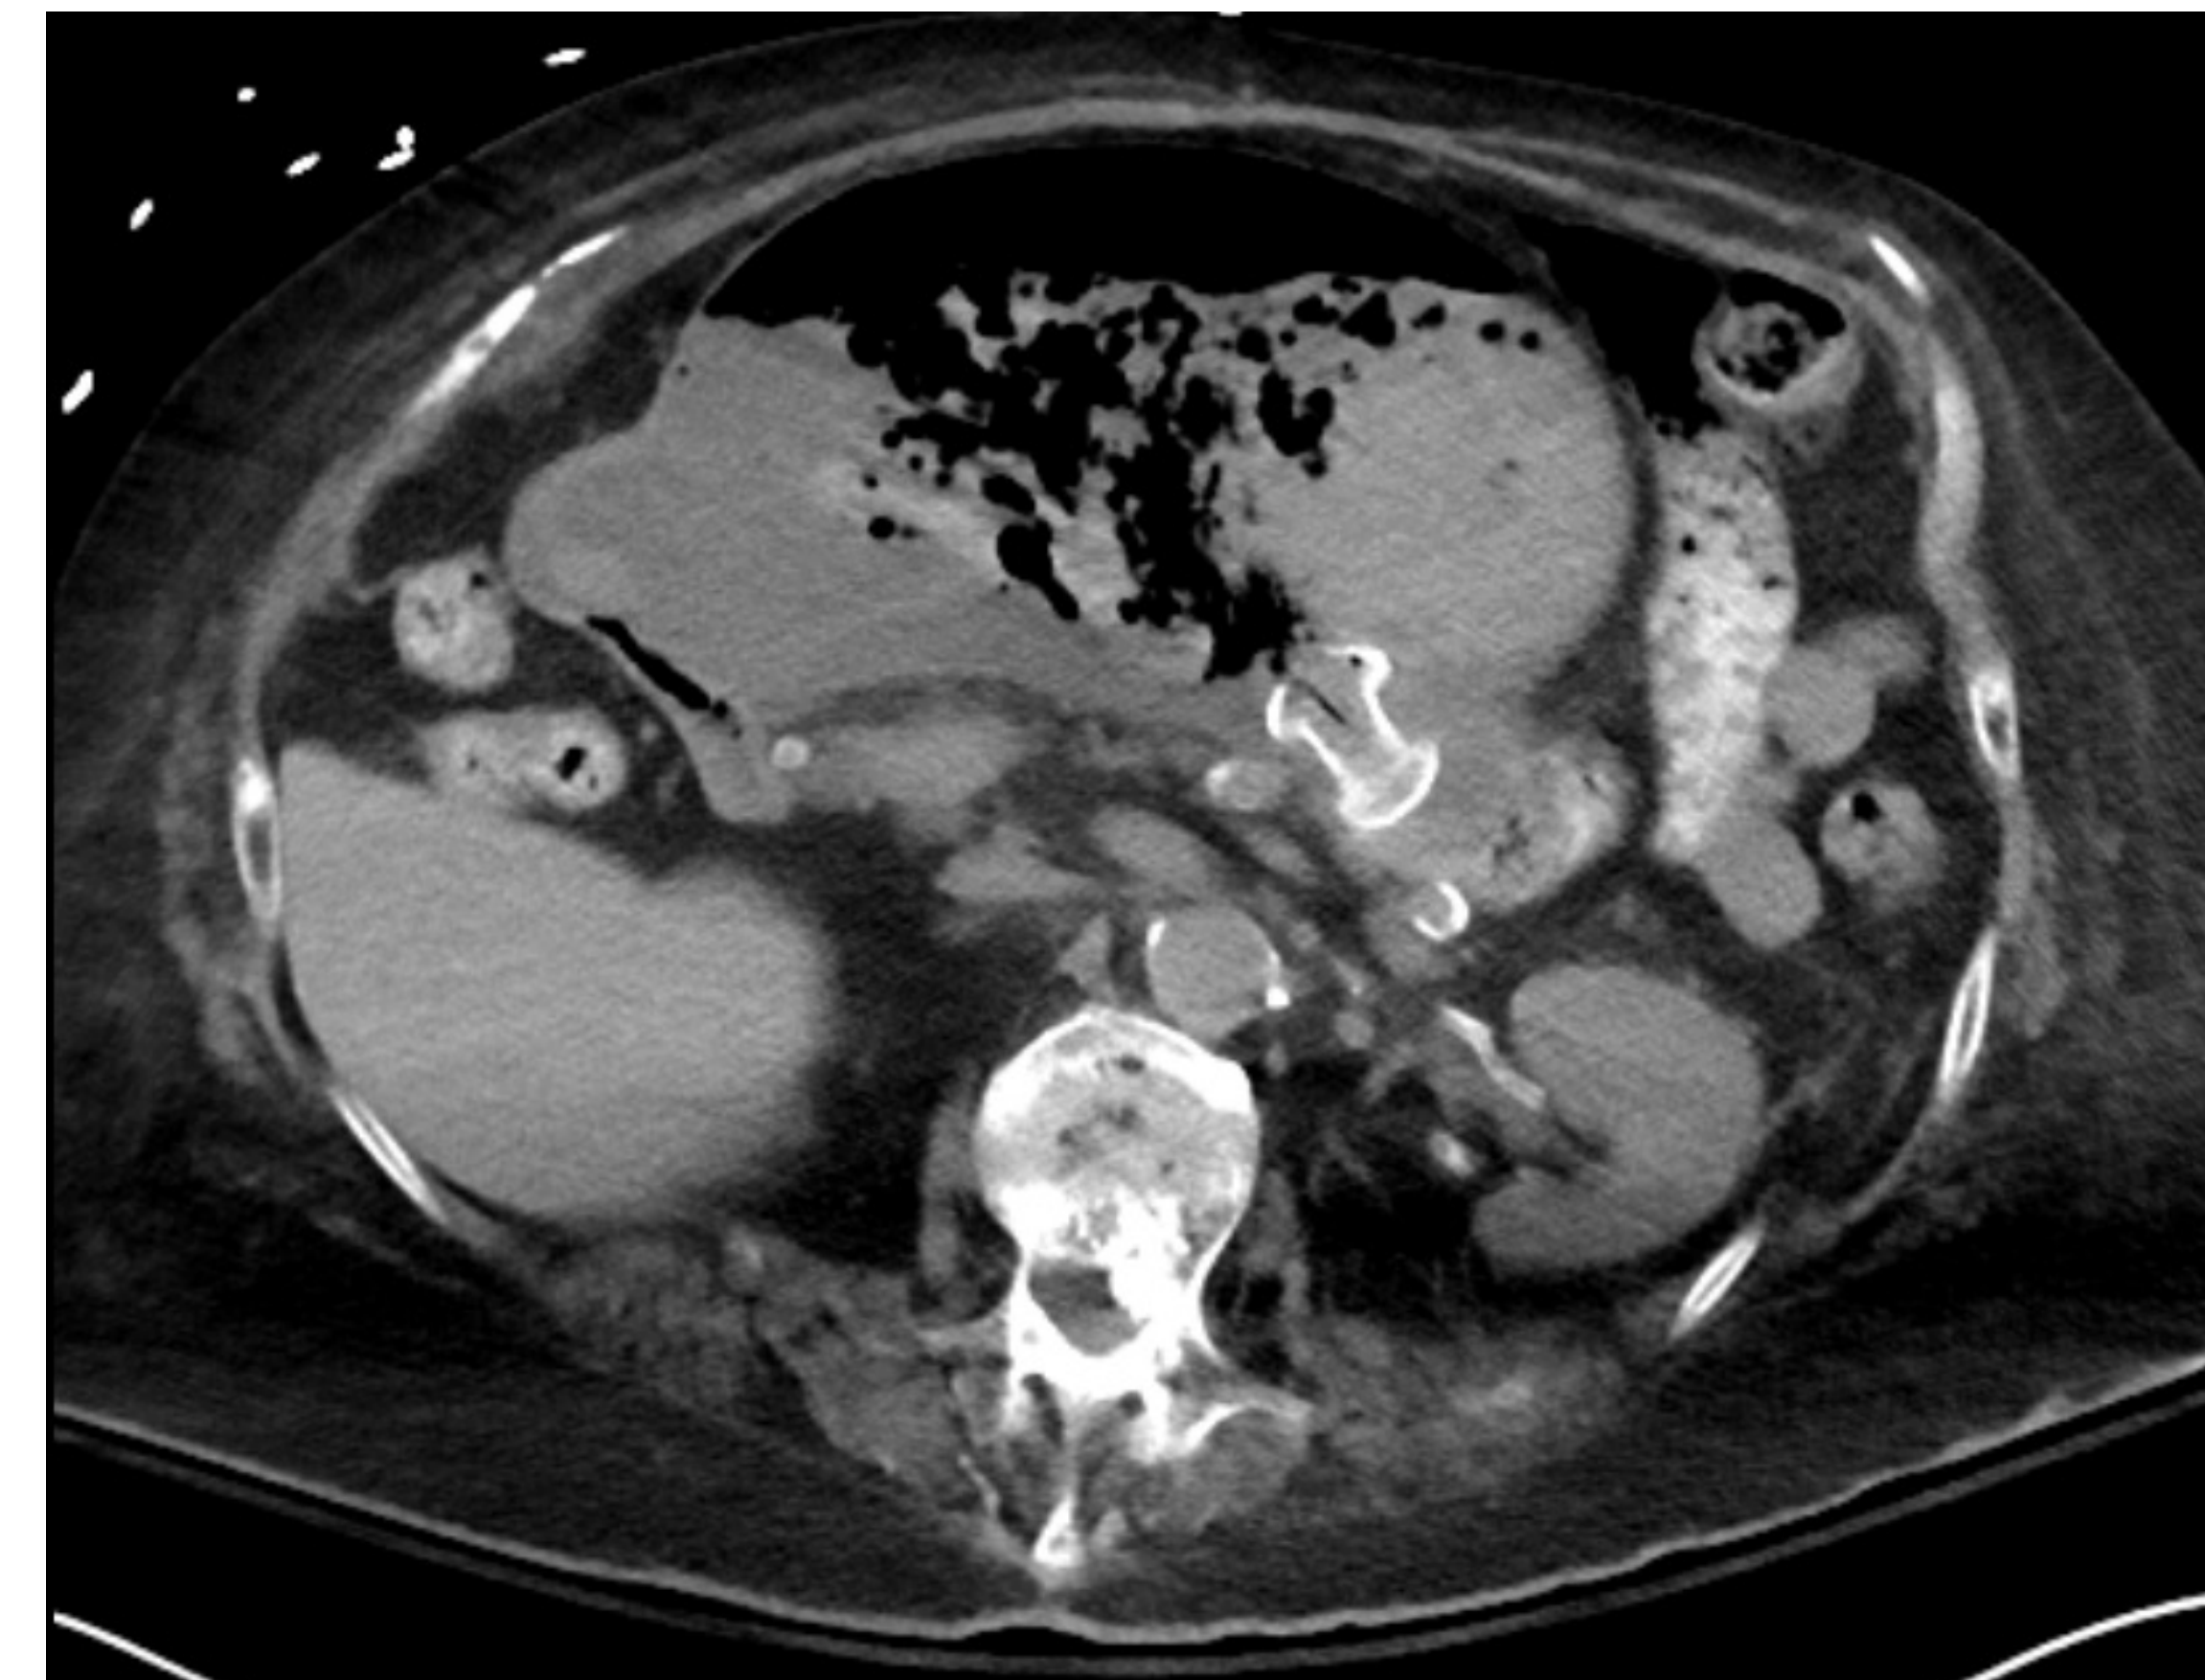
CT scan with worsened dilatation of the bypassed excluded stomach after stent placement
